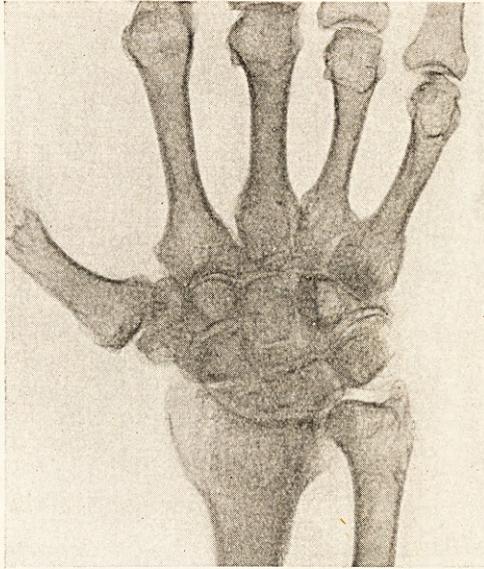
Case VII. (Mrs C.). X-ray of same wrist three years after original injury. The osteodystrophy is now healed, but the joint is ankylosed. Note deposits of calcium in capsule bridging the gap between the navicular and lunate and the lower end of the radius.
